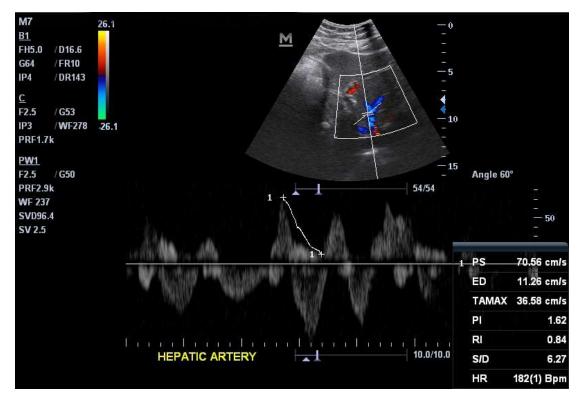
53year old male. Doppler ultrasound demonstrates a slightly increased HARI of 0.84
